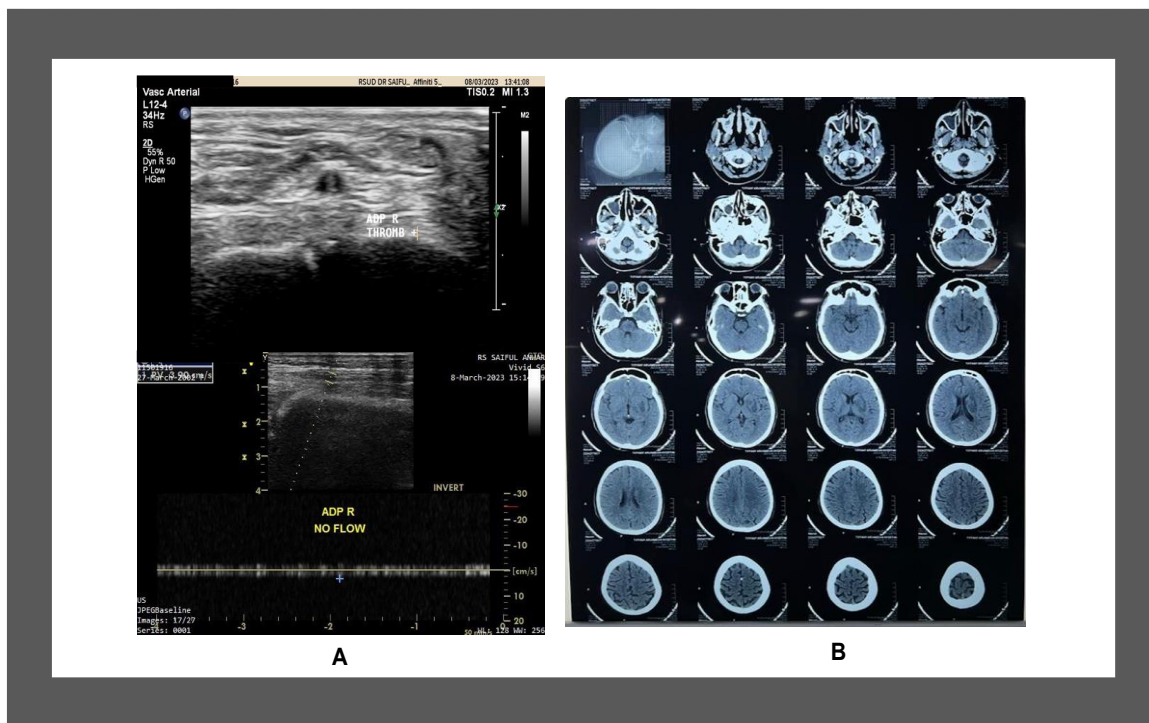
(A) The duplex ultrasonography examination showed the presence of a thrombus within the right dorsal pedis artery. (B) A head CT scan indicated the presence of an acute infarct in the left internal, external capsules and left corona radiata
